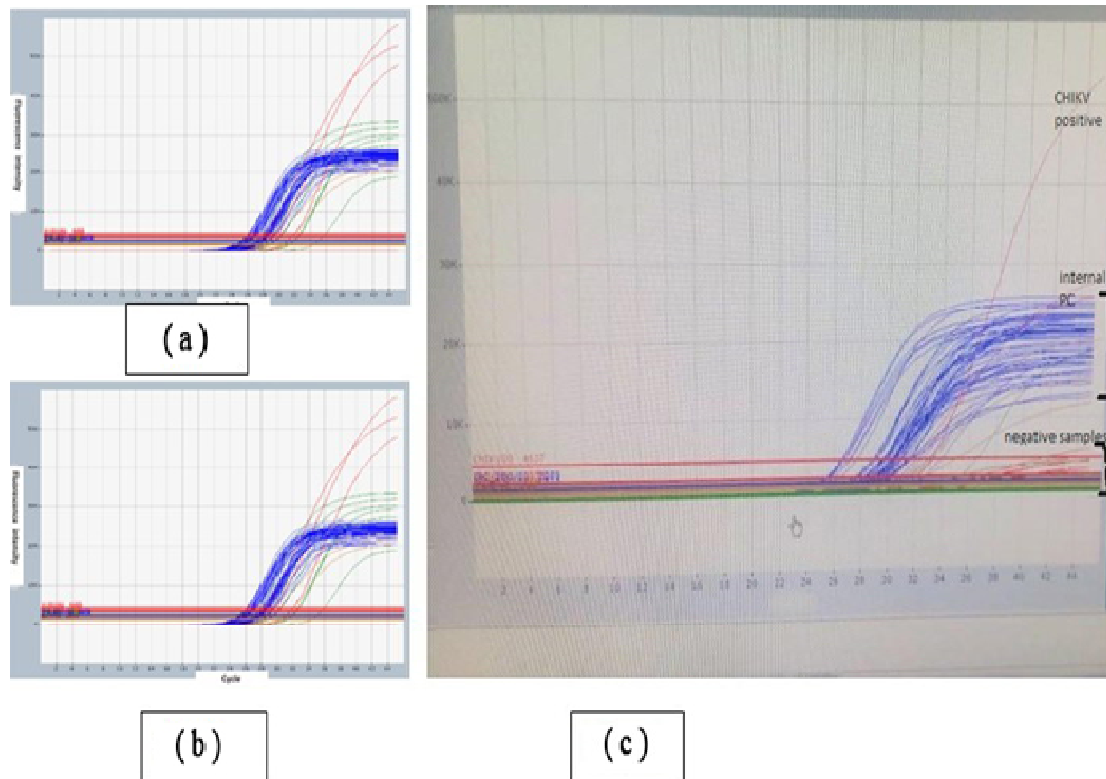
a; The amplification plot of multiplex real-time RT-PCR results, where each colour represents a specific virus, Green- DENV, Blue-IPC, Red- CHIKV, and Brown- ZIKV. b; the amplification plot of Multiplex real-time RT-PCR showing the internal positive control and (CHIKV & DENV) negative samples. c; The amplification plot of Multiplex Real-time RT-PCR of positive CHIKV showing the internal positive control and CHIKV positive samples as the CT values indicated in Table 2
